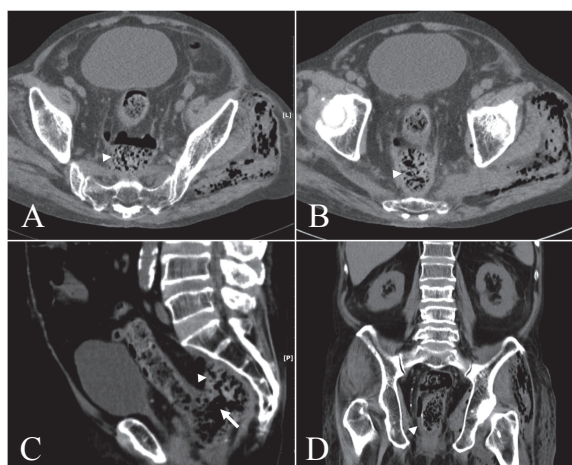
(A–D) axial view, corona view and sagittal view of abdominal computed tomography (CT) without contrast. The figure showed air-containing perirectal abscess (arrow head) which communicate with pararectal space. (C) It displayed the posterior rectum wall was separated as well (arrow). The air dissected into pelvic floor with extension to the left lower extremity.
